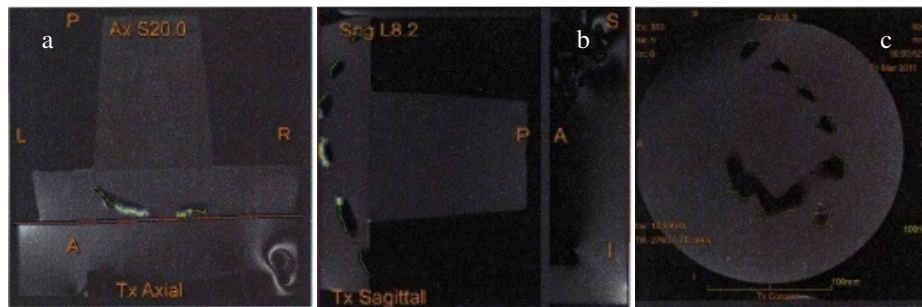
ExAblate 2000 System: MR images showing the experimental setup with the epoxy rib cage mimics (a- coronal, b- sagittal and c- axial planes).
